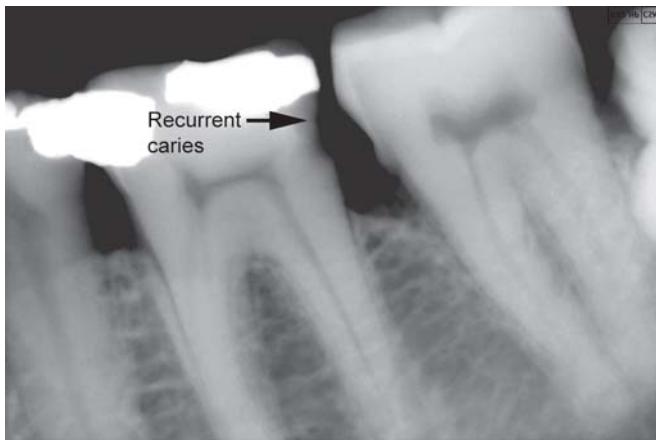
Radiograph showing recurrent caries adjacent to proximal restoration
